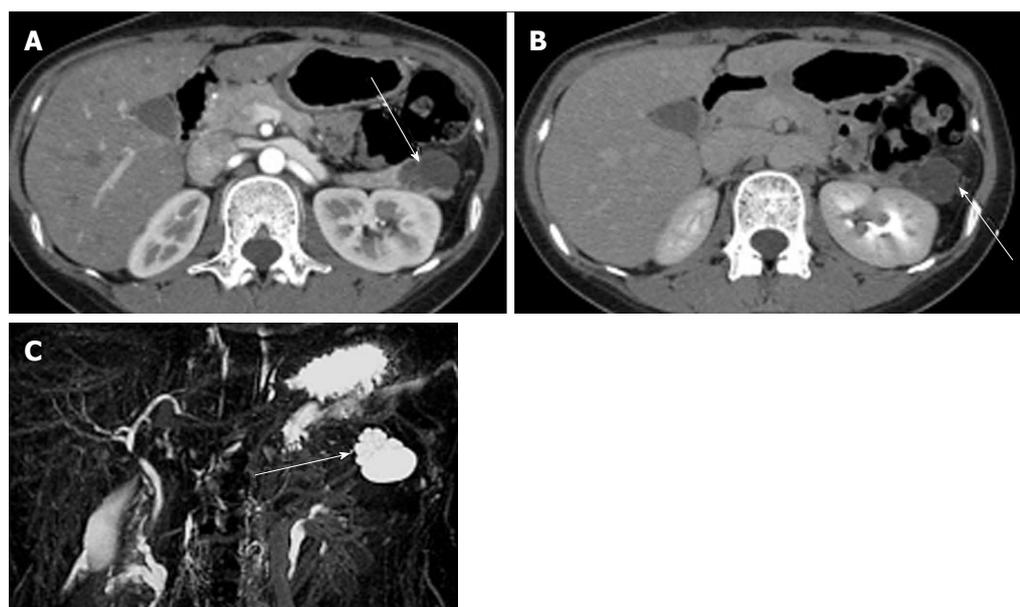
A 27-year-old female with mixed microcystic and macrocystic serous cystic neoplasm. A: The pancreatic parenchymal phase of an axial contrast enhanced- computed tomography shows a lobulated cystic mass (arrow) in the pancreatic tail; B: The equilibrium phase shows no cyst wall enhancement (arrow); C: Magnetic resonance cholangiopancreatography clearly shows a cluster of microcysts (honeycomb pattern) in the peripheral portion of this cystic lesion (arrow).
